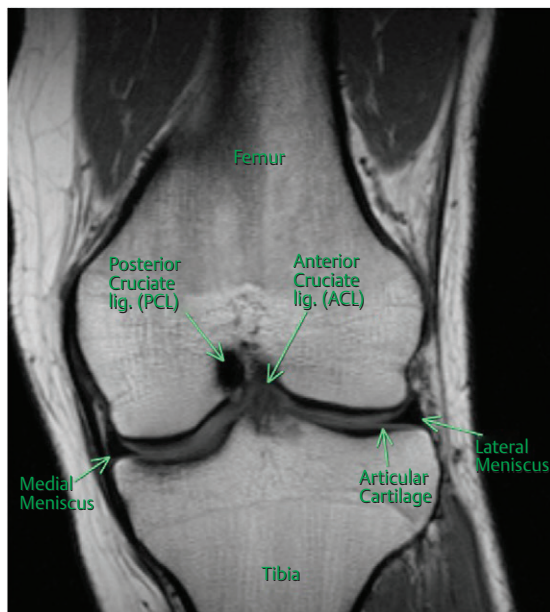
Radiograph of the right knee
